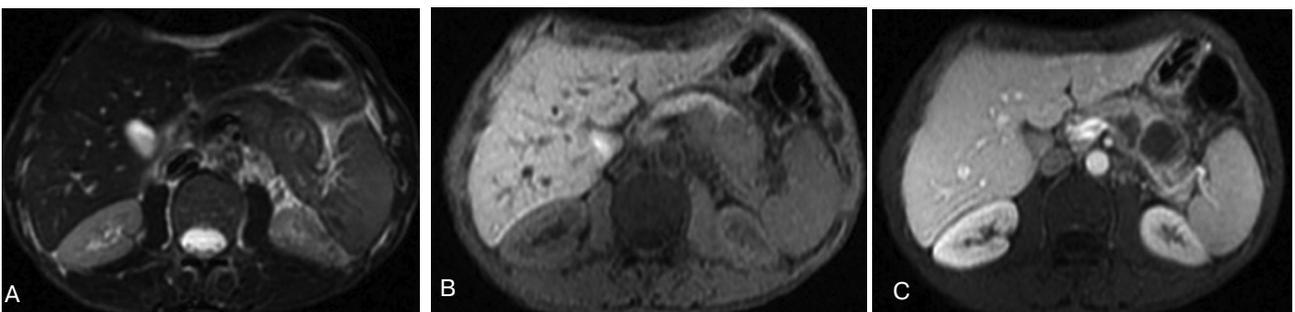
Pancreatic metastases of non-small cell lung cancer. A. T2-weighted MR image shows a slightly hyperintense lesion in the tail of the pancreas. B. On T1-weighted image the lesion appears hypointense. C. After i.v. administration of gadolinium, the lesion is clearly depicted
